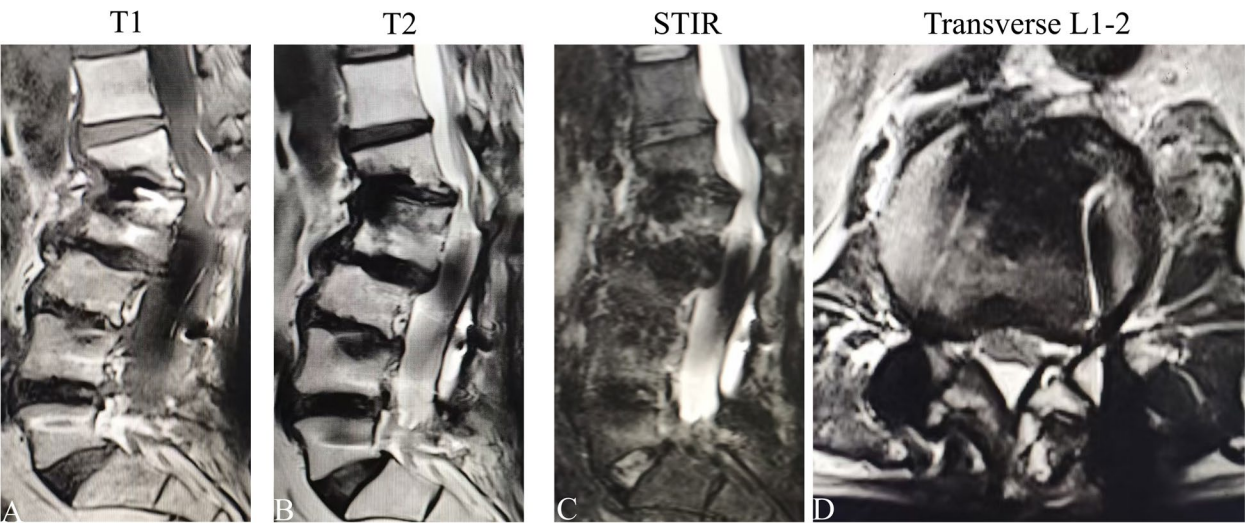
MRI was performed at the last postoperative follow-up, and there were no signs of infection on sagittal (A, B, C) or transverse (D) scans
